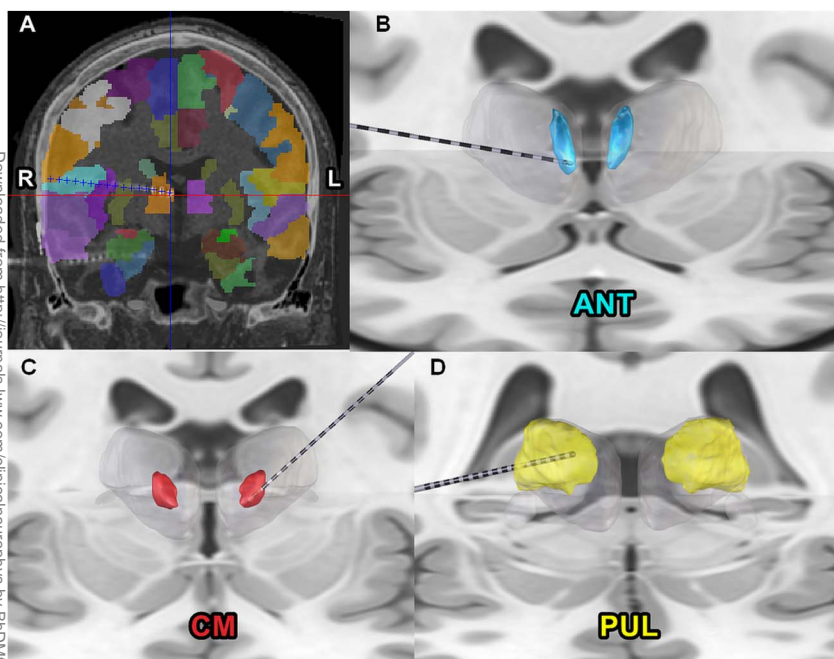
Anatomical localization of SEEG electrodes targeting thalamic nuclei. A, Postimplant CT was co-registered with the preimplant MRI, and SEEG electrode trajectories were extracted (blue cross hairs). Trajectory of the electrode targeting the ANT: entry through pre-central gyrus, traversing frontal operculum, insula, and putamen to reach the anterior ventral segment of the anterior nucleus of the thalamus—ANT. B, SEEG electrodes reconstructed in 3D using LeadDBS,⁶⁴ with the cyan ROI representing the ANT. C, SEEG electrode ending in the CM (red ROI). D, SEEG electrode targeting the pulvinar thalamus (yellow ROI) that tracks through the lateral pulvinar to end in the medial pulvinar. CM, centromedian thalamus; CT, computerized tomography; MRI, magnetic resonance imaging; ROI, region of interest; SEEG, stereoelectroencephalography.
